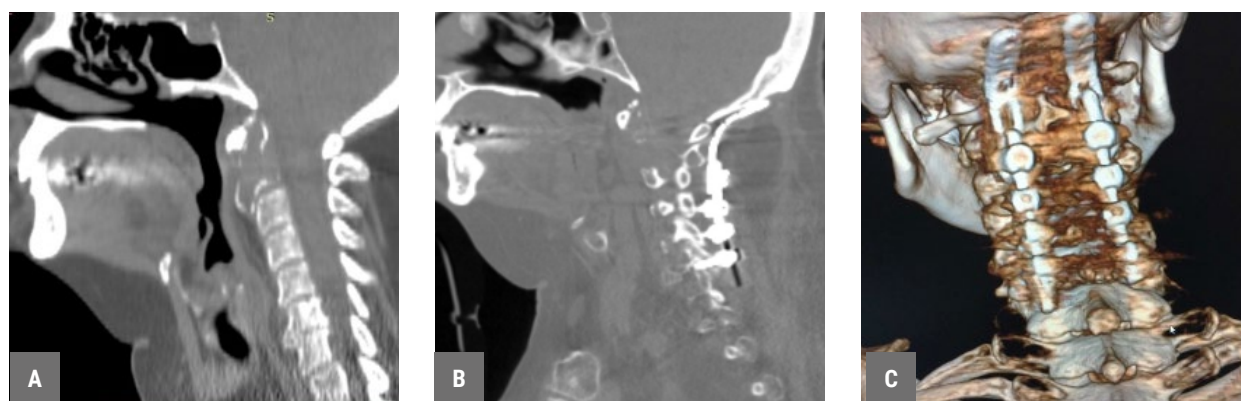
Occipitospondylodesis in patient No. 3. A – computed tomography data before surgery. B, C – computed tomography data after the surgery.
